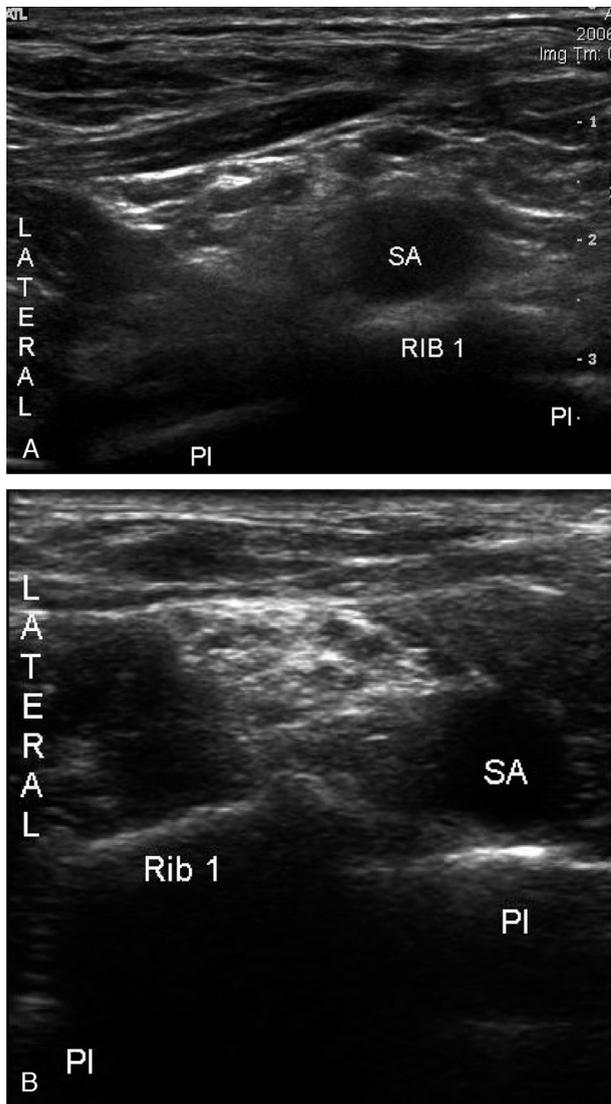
A, Ultrasound image corresponding to probe position A. Note the subclavian artery and brachial plexus on the first rib. B, Ultrasound image corresponding to probe position B. Note the subclavian artery and brachial plexus on the pleura. SA indicates subclavian artery; PL, pleura.
